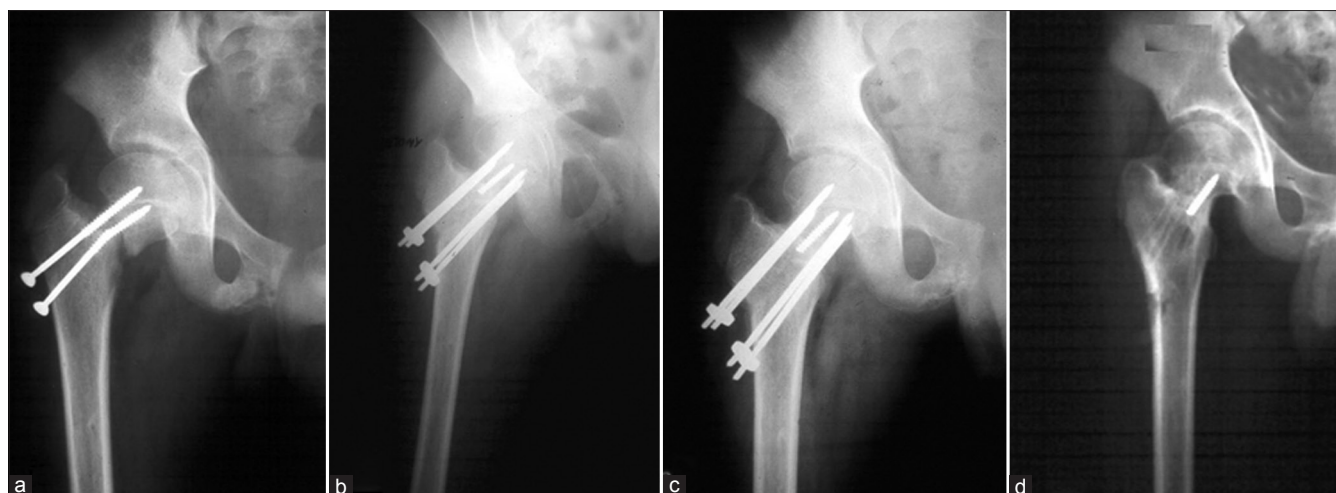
X-ray right hip joint in a 12 year old male child showing (a) nonunion since nine months; failed screws *in situ*; neck shaft angle 116°, (b) TFAO done, (c) seven months postoperatively, union achieved and neck shaft angle restored to 130°, (d) status at eight months after removal of implants
